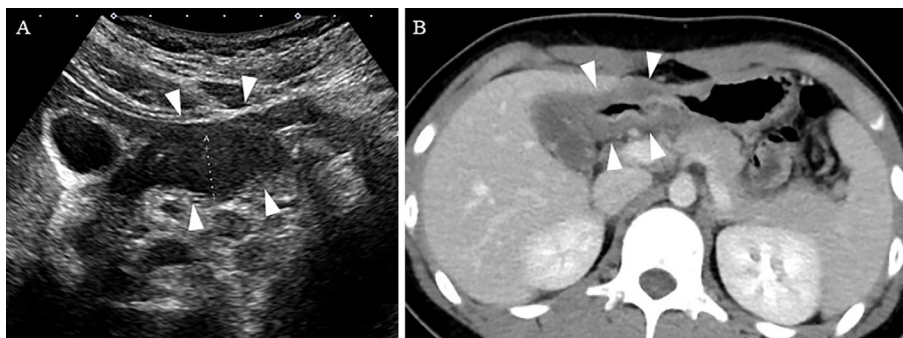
Ultrasonography (US) and computed tomography (CT). US and CT revealed thickening of the duodenal wall, but no ascites (A, B).
